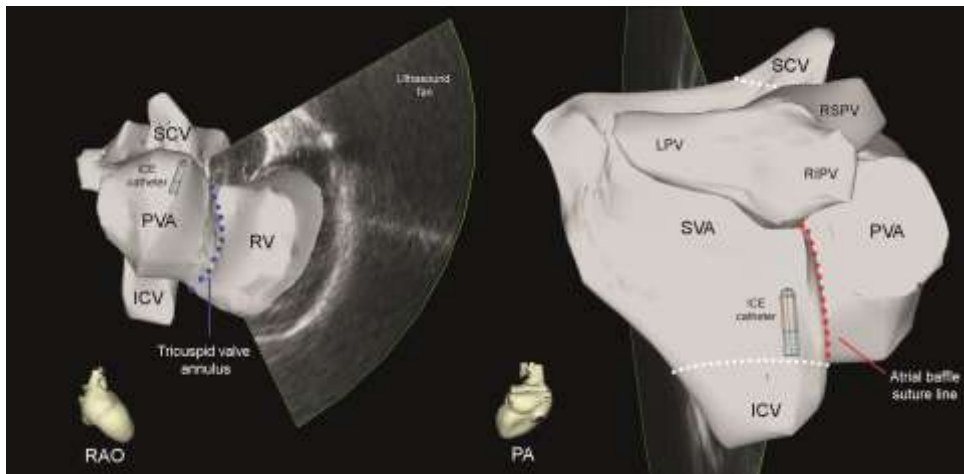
A three-dimensional shell of the cardiac anatomy created with intracardiac echocardiography (ICE). Positioning the ICE catheter inside the systemic venous atrium (SVA), anatomical and surgical lines of conduction block were identified such as caval veins, tricuspid valve annulus and atrial baffle suture line. ICV = inferior caval vein, LPV = left pulmonary veins, PA = posterior-anterior view, PVA = pulmonary venous atrium, RAO = right anterior oblique view, RIPV = right inferior pulmonary vein, RSPV = right superior pulmonary vein, RV = right ventricle, SCV = superior caval vein.
